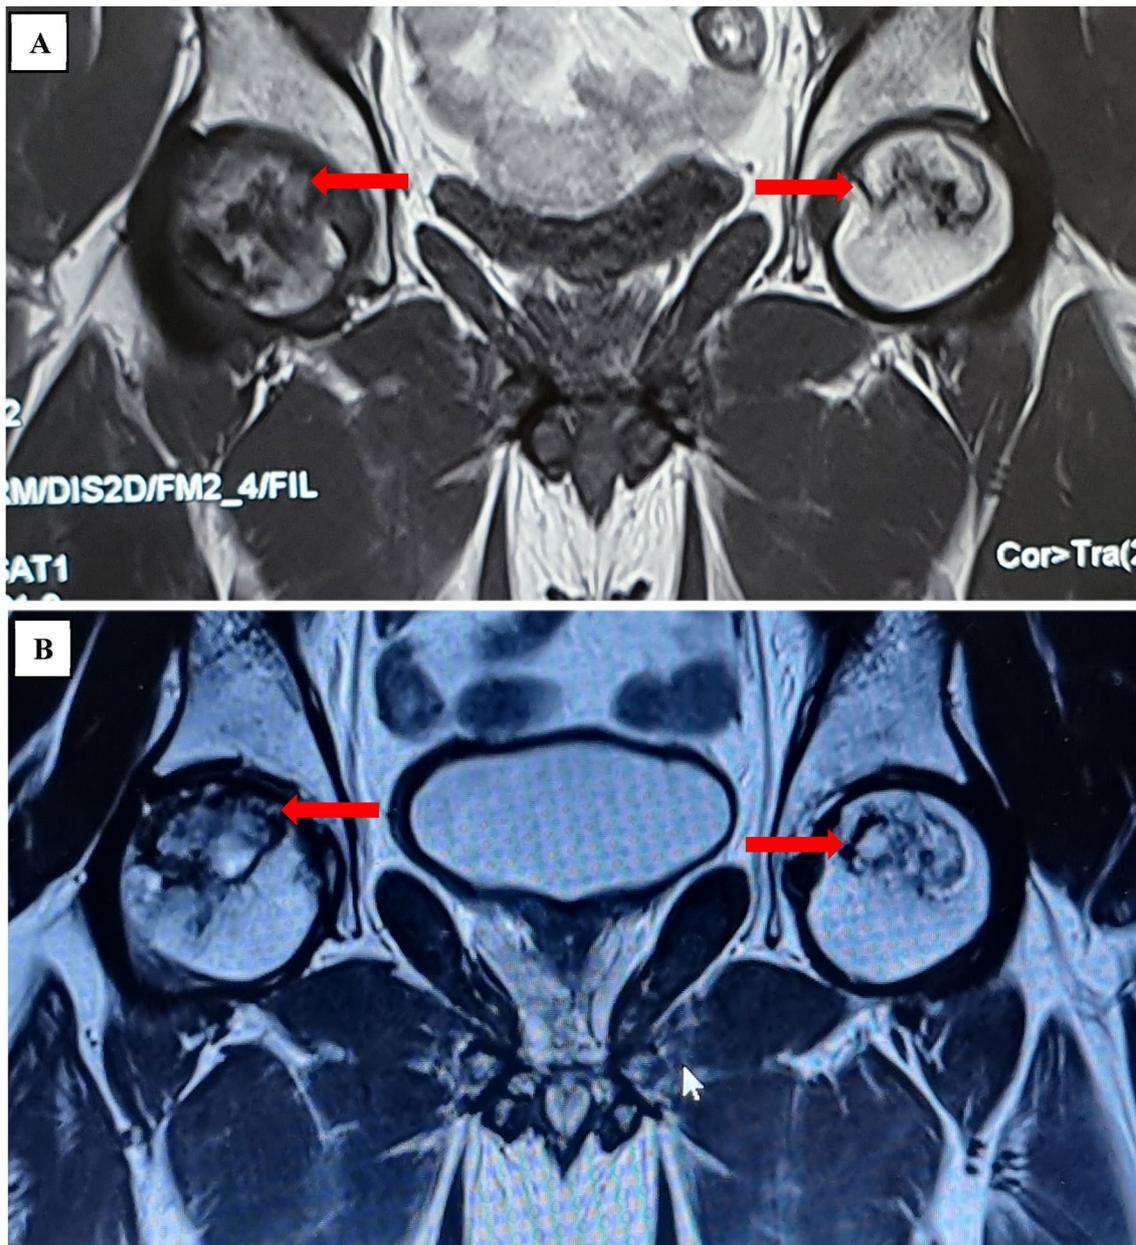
A Pre-operative MRI of the pelvis with bilateral hips showing grade 2b avascular necrosis of bilateral femoral heads and B 36th-month follow-up MRI of the pelvis with bilateral hips showing
